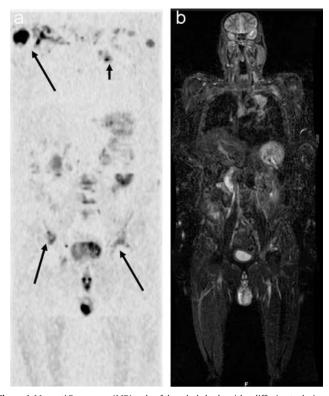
Magneti Resonance (MR) sudy of the whole body with a diffusion technique. a) MR image with diffusion and inversion of contrast, showing a left primary lung neoplasia (small arrow) with multiple diffuse bone metastasis (long arrows). b) Whole body MR with STIR (short tau inversion recovery) sequence complementing the diffusion sequence, showing a greater anatomical detail of the left lung neoplasia.
